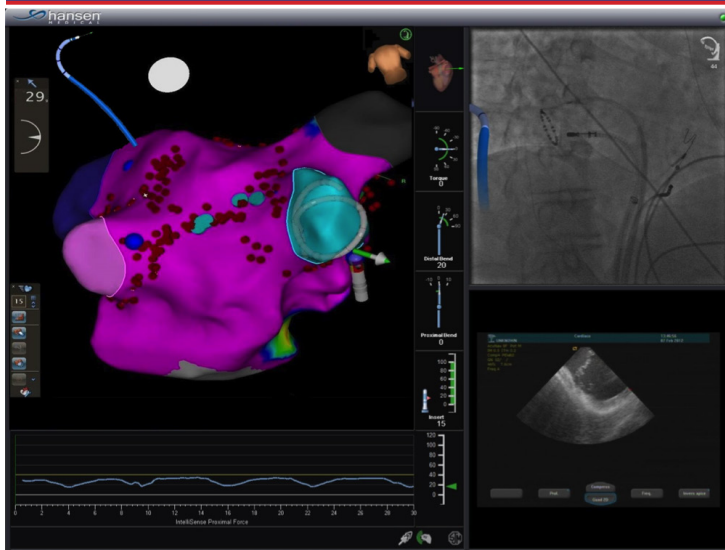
The robotic Sensei X system (Hansen Medical, CA) screen shot. On the left, left atrium as drawn with CARTO System. Upper right, fluoroscopy view. Bottom right, intracardiac echocardiography.
